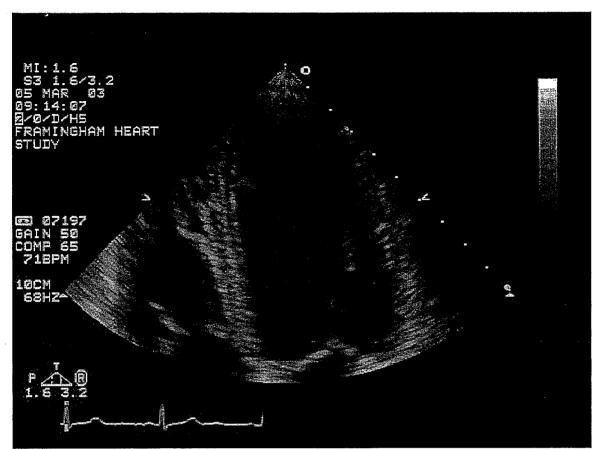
Example of 2-D Apical Four-Chamber view of LV. Image is on-axis with clear definition of apical endocardium and mitral valve annulus and leaflets are clearly shown. Longitudinal measurement is made from apex to imaginary line across mitral annulus. (optimal image)
